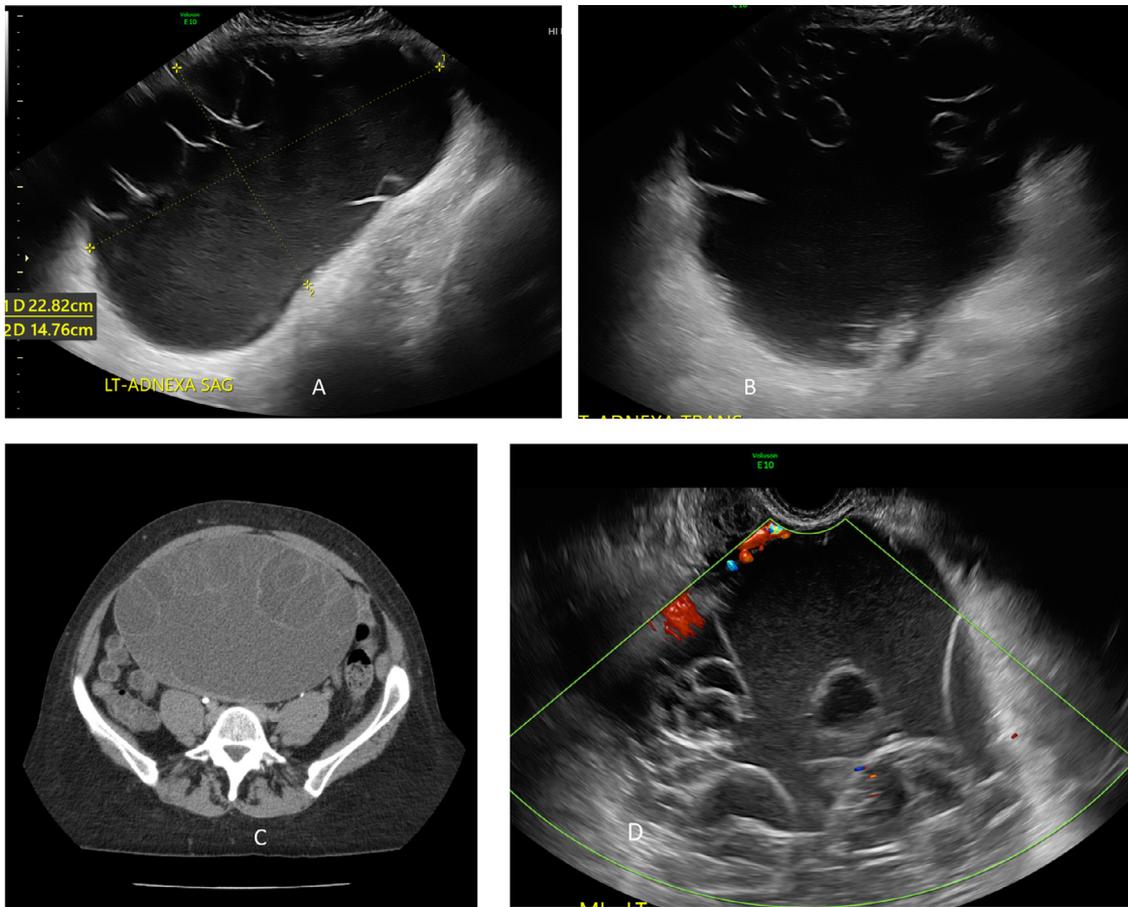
Large multiloculated cystic ovarian tumor without solid components and minimal vascular flow. There was no associated ascites. Surgical diagnosis was a borderline mucinous cystadenoma. (A) Sagittal and (B) transverse ultrasound images. (C) Axial CT scan image. (D) Color Doppler score of 1 with no flow observed within the septations.
